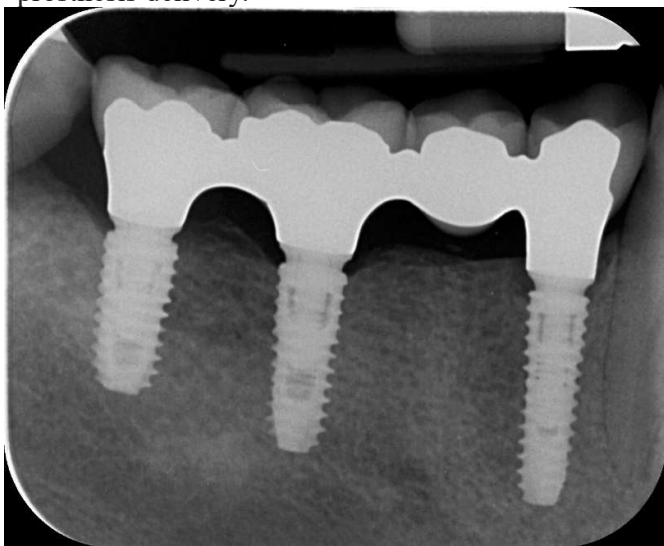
Case 2: periapical radiograph at the 5-year follow-up.
